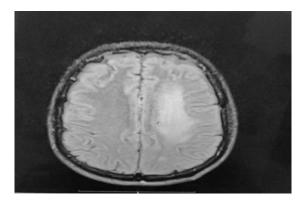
MRI BRAIN T1 with Gadolinium enhancement showing predominant left sided white matter lesion in Parietal lobe. (Not shown here: Nil resolution of Cerebellar lesions)
